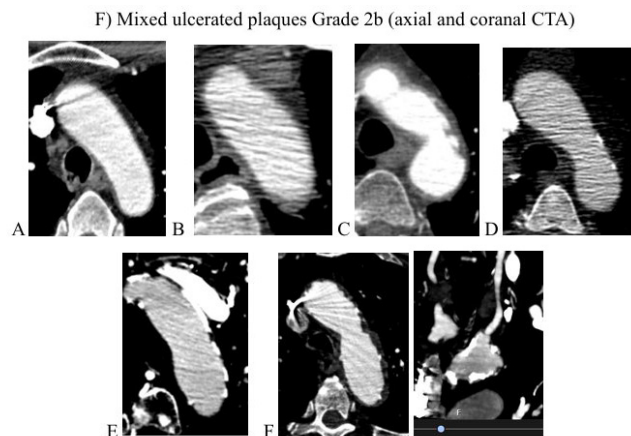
A: Axial CTA image showing normal aortic arch (Magnification: 600 DPI). B: Axial CTA image showing pure soft plaques (Grade 1a) (Magnification: 600 DPI). C: Axial CTA image showing pure soft and ulcerated plaques (Grade 1a) (Magnification: 600 DPI). D: Axial CTA image showing purely calcified plaque (Grade 1b) (Magnification: 600 DPI). E: Axial CTA image showing purely calcified plaque (Grade 2b) (Magnification: 600 DPI). F: Axial and coronal CTA images showing mixed ulcerated plaques (Grade 2b) (Magnification: 600 DPI).
